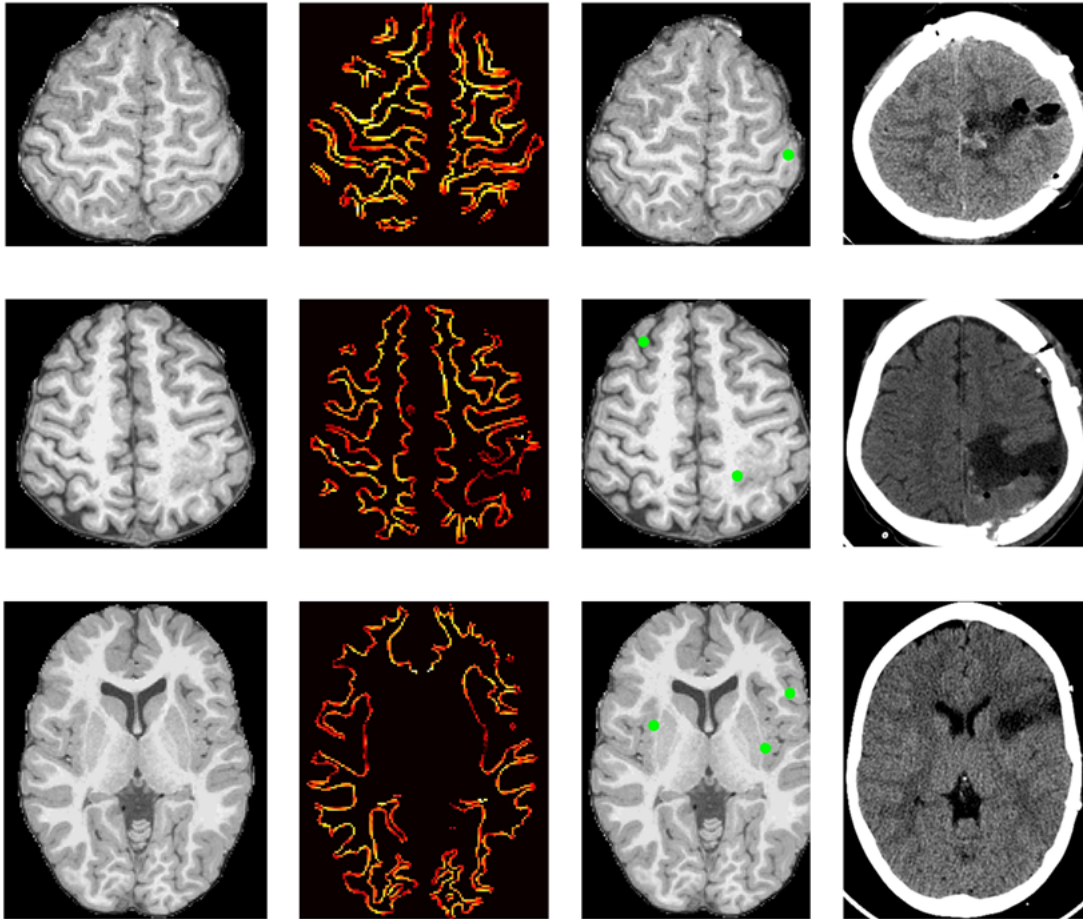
Results of volumetric T1 MRI processing using blurring of gray-white matter interface. (Column 1) Original MRI image after normalization and skull stripping , (Column 2) Showing gradient magnitude measurements on interface (Column 3) Original image with green overlay indicating vertices identified by program to indicate lesion, (Column 4) surgical resection site on post-operative CT or T1 scan. Scan indicating location of lesion was removed
